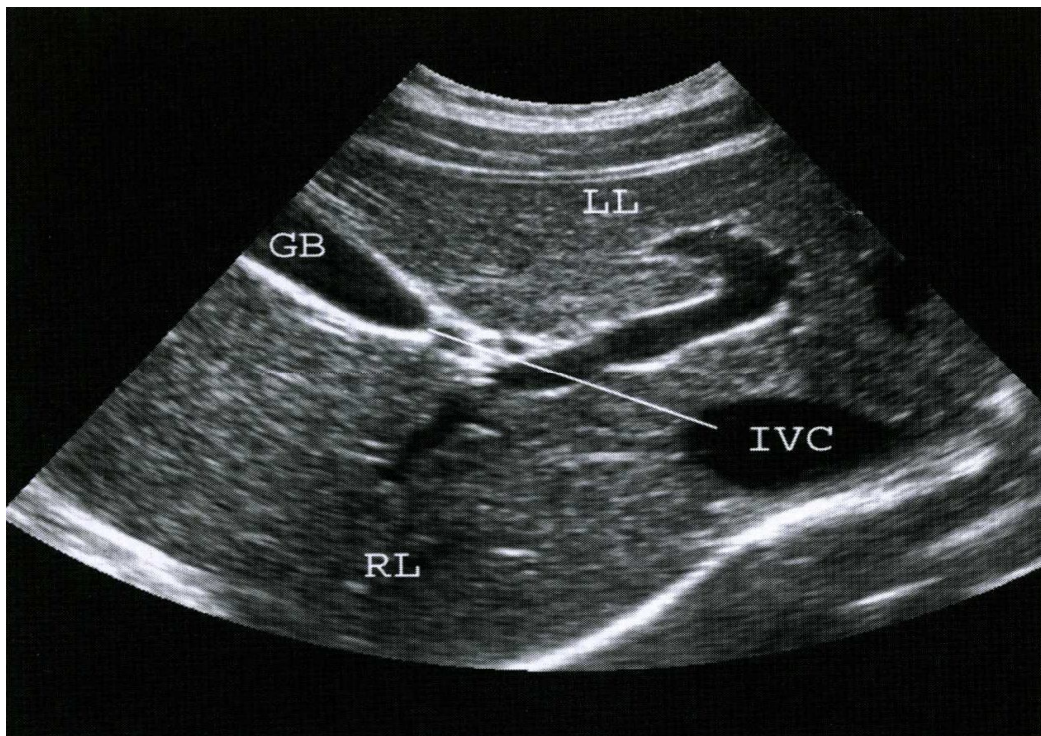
Ultrasound image of the main lobar fissure (Rumak et, al2005)
